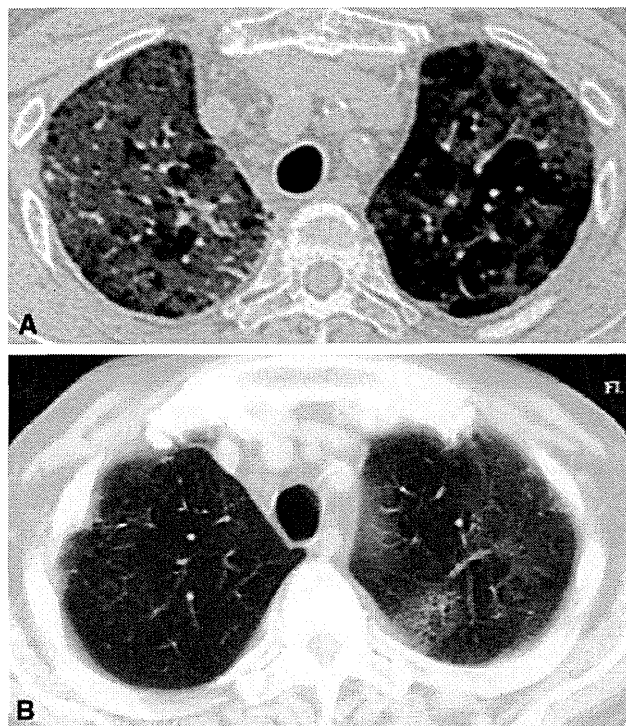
Thoracic computed tomography findings of rheumatoid arthritis patients who developed *Pneumocystis jirovecii* pneumonia while receiving etanercept. a Ground-glass opacity (GGO) with sharp demarcation by interlobular septa and geographic pattern. b GGO without interlobular septal boundaries
